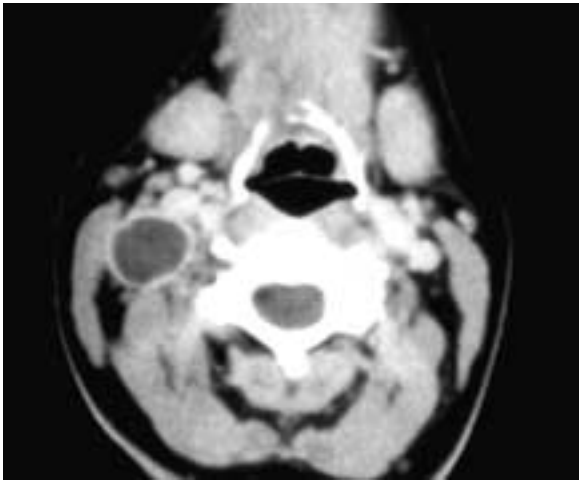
Axial contrast-enhanced CT scan shows a “cyst” in the right neck, completely deep to the sternocleidomastoid muscle, dorsal to the carotid sheath structures, and not touching the submandibular gland. Clinically, this was thought to be a second branchial cleft cyst, but the location of the lesion on the image is not that of a second branchial cleft cyst. This was a metastatic papillary thyroid carcinoma lymph node.
